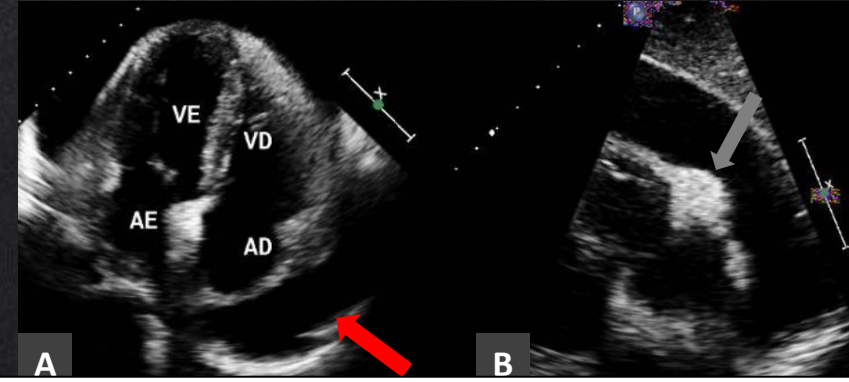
33-year-old woman with antecedent of lymphoproliferative disease presents with thoracic pain 2 days ago. Echocardiography shows an important pericardial effusion (A) - (red arrow) and a nodular lesion in visceral pericardium (B) - (gray arrow), suspicious for secondary involvement.
